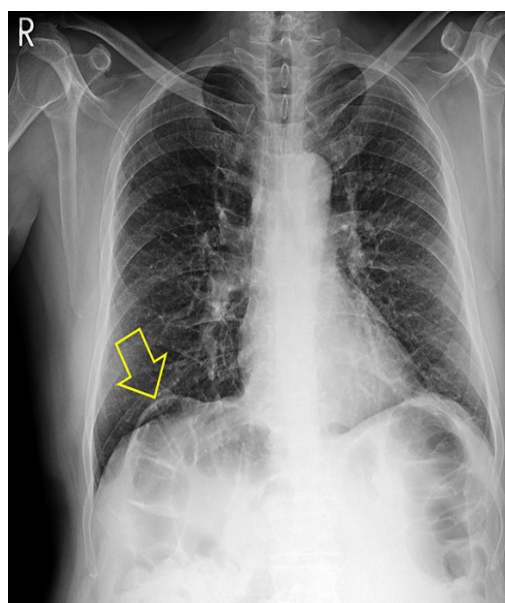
The interposition of a segment of the colon between the liver and the right hemidiaphragm (arrow), the Chilaiditi sign. The chest radiograph is otherwise normal.
